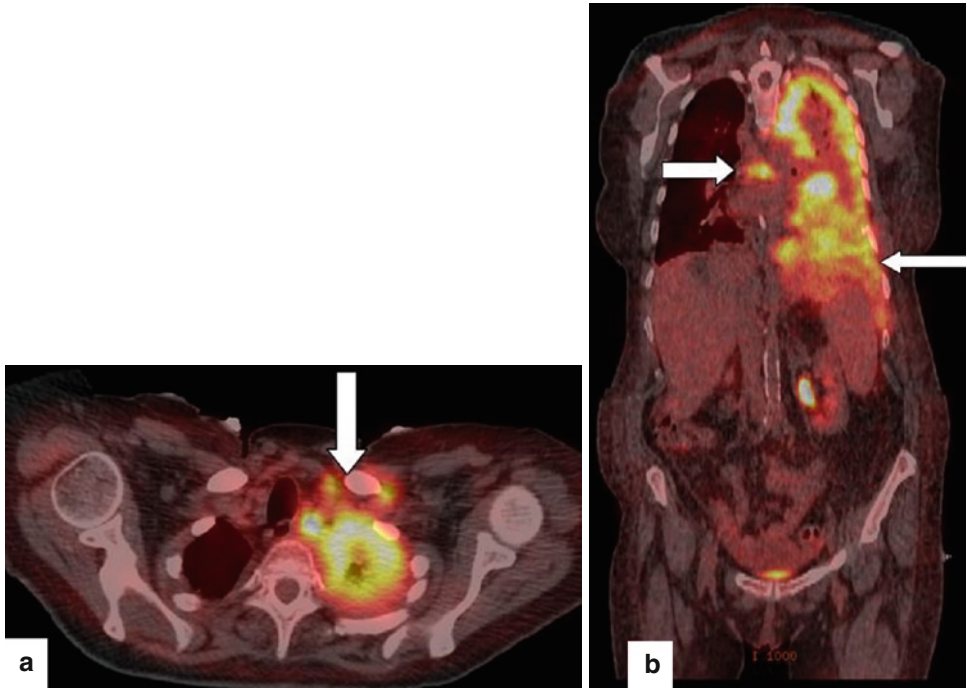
(a) and (b) Fused ^{18}F -FDG images in a patient with advanced epithelial MPM, with left supraclavicular nodes (*arrow*), mediastinal nodes, and intra-abdominal extension (*arrows*)
